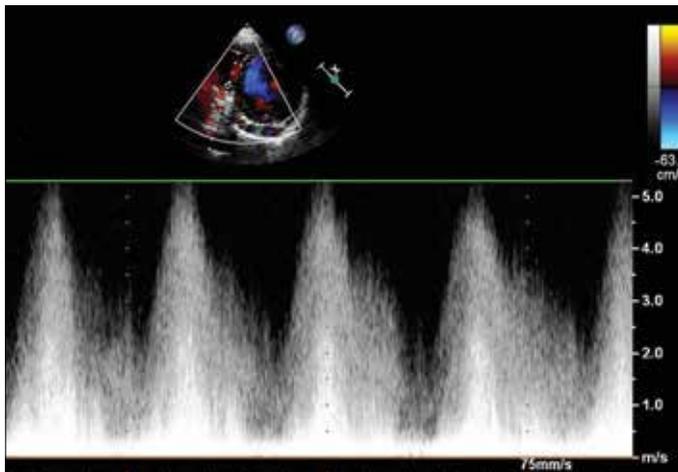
Continuous-wave Doppler echocardiography revealed blood flow spectrum of high-speed continuous at the drainage site
